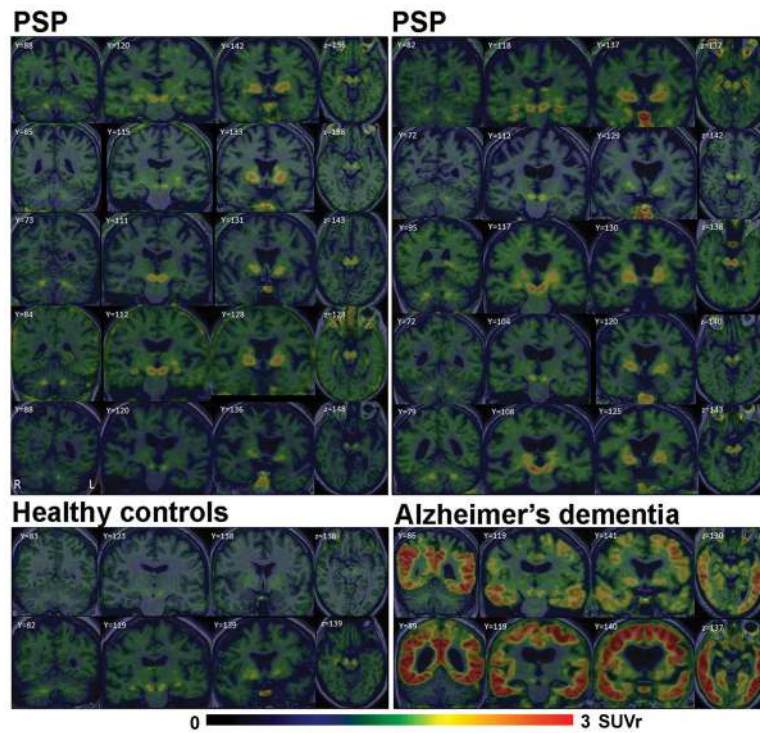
Individual tau-PET images for the 10 PSP patients, two healthy controls and two Alzheimer's dementia patients. Coronal images at the level of the dentate nucleus of the cerebellum, midbrain and basal ganglia, as well as an axial image at the level of the midbrain, are shown. All images are shown on the same SUVr scale (0–3).
